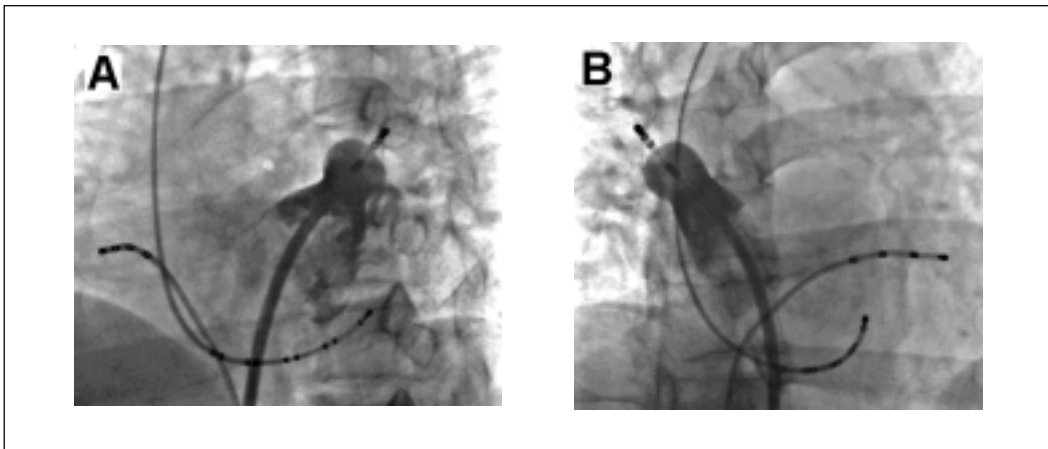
Ultrasound balloon location under the guidance of target pulmonary vein ostium angiography. (A) Left superior pulmonary vein ostium ablation under 45° left anterior oblique projection. (B) Right superior pulmonary vein ostium under 60° left anterior oblique projection.*
